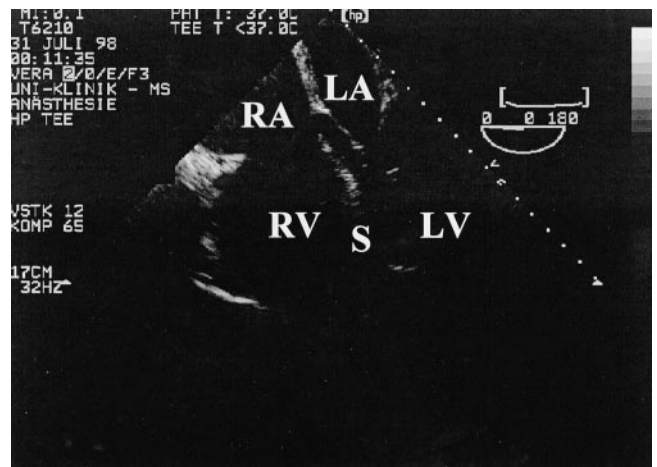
Transesophageal echocardiography for diagnosis of pulmonary hypertension. Dilated right ventricle (RV) in the midesophageal four chamber view. The figure shows the classical septal (S) interventricular shift to the left side. RA = right atrium, LA = left atrium, LV = left ventricle.
